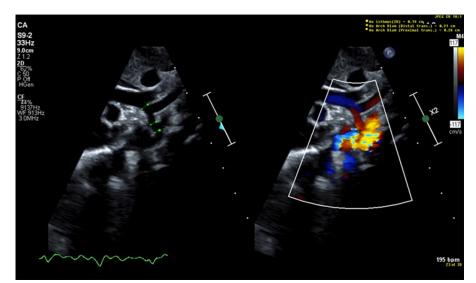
Two-dimensional transthoracic echocardiogram suprasternal notch view (2-D on the left; color flow Doppler on the right) done prior surgical intervention. Demonstrating moderate transverse arch hypoplasia, aortic coarctation with distal displacement of the left subclavian artery, a patent ductus arteriosus with flow acceleration and retrograde flow into aortic arch.
